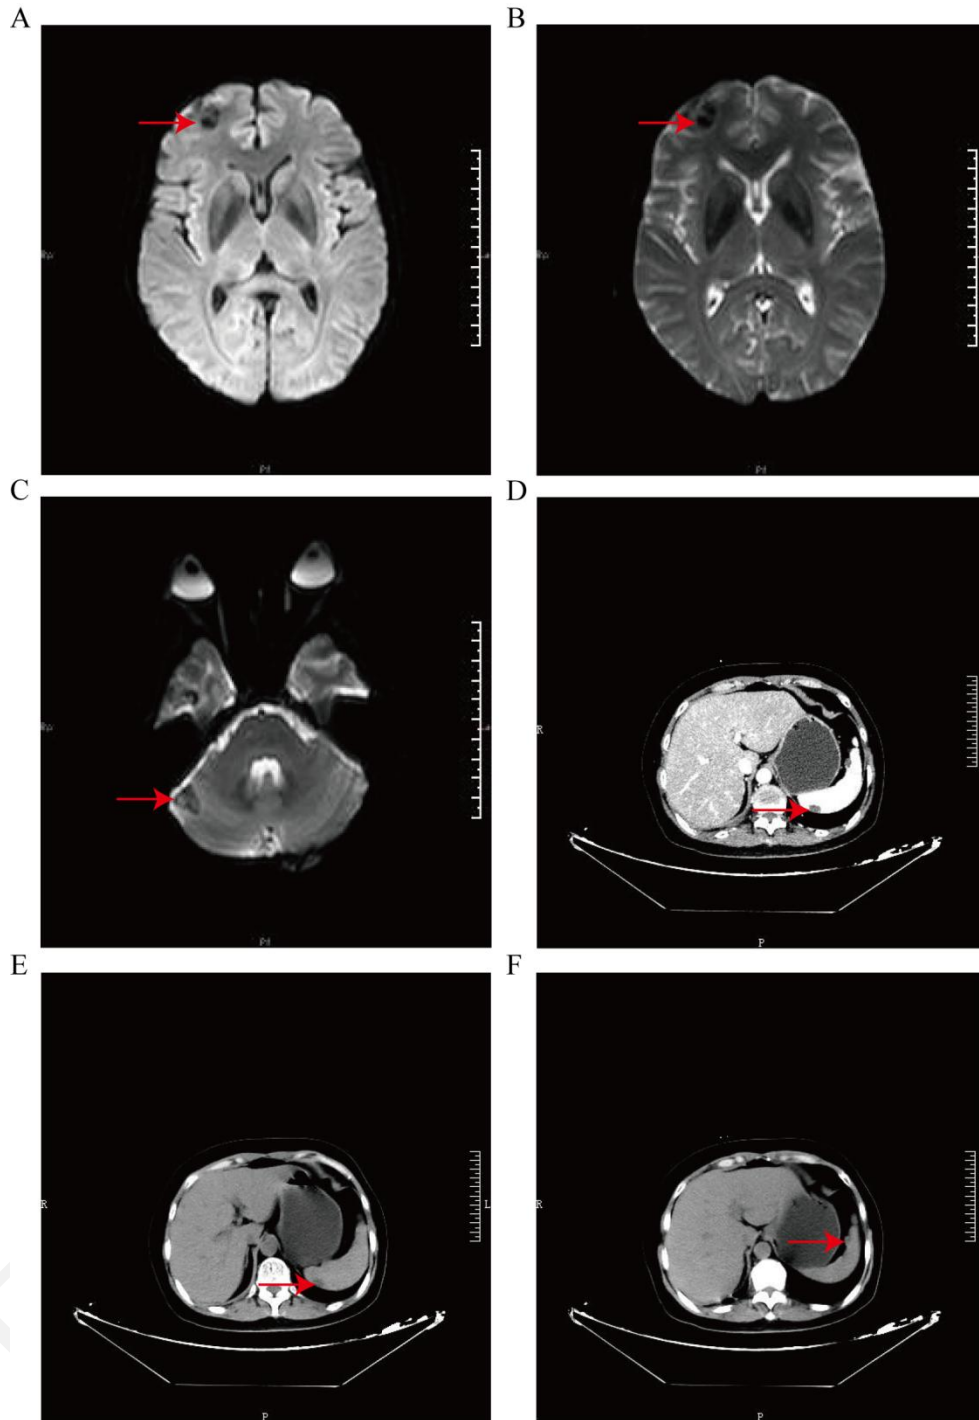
Radiographic data from case 4. CT and MRI images. These radiographic data demonstrate that metastasis occurred in the brain and spleen. (A-C) MRI images indicate metastasis occurred in the brain. (D) Cross-sectional contrast-enhanced arterial phase CT of the abdomen. Metastasis can be observed in the spleen (arrow). (E-F) Cross-sectional contrast-enhanced venous phase CT of the abdomen. Metastasis can be observed in the spleen (arrow).
